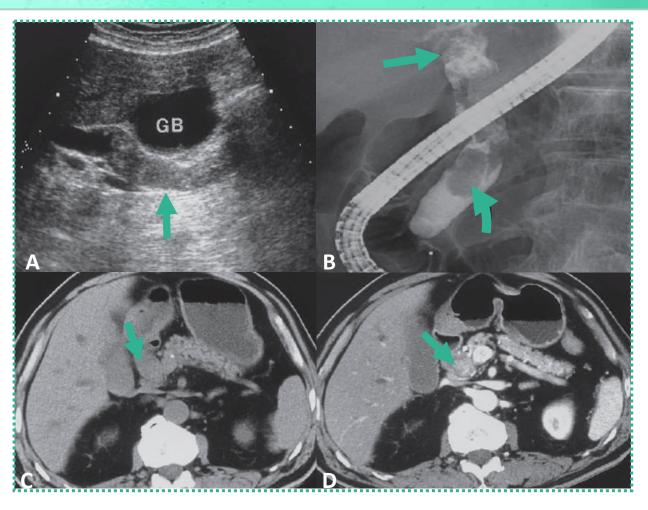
Ultrasound (A), ERCP (B), CT (C=non-contrast-enhanced, D=contrast-enhanced images) – Intraductal polypoid cholangiocarcinoma.
